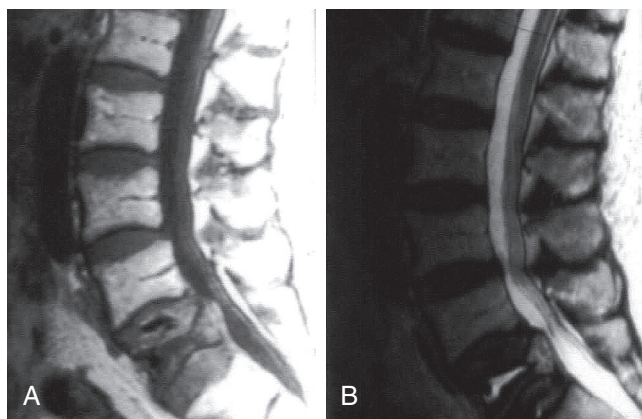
■ Benign compression fracture. Sagittal T1-weighted (A) and T2-weighted (B) magnetic resonance imaging scans demonstrate compression fracture of L5. Compare signal characteristics of remaining bony elements and pedicles with signal of normal bony structures.
